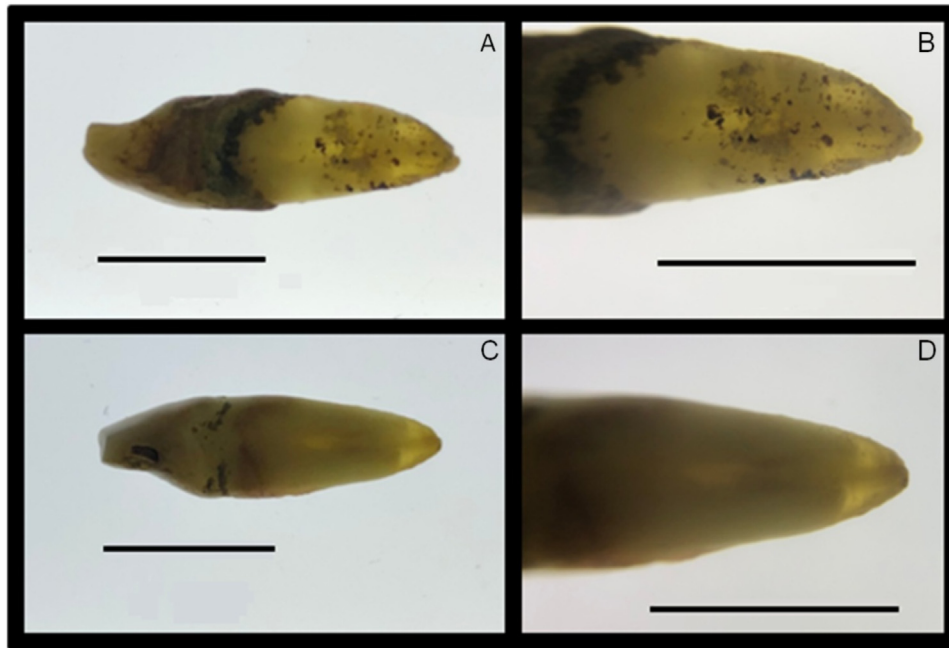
The figure represents the dental transluency as seen macroscopically in an LED X-ray viewer. A–B show a tooth that exhibits equal amount of dental transluency in both labial and lingual surfaces. On the other hand C–D represent a tooth where lingual surface exhibits a slightly greater amount of dental transluency in comparison to the labial surface. The black line represents 1 cm.
